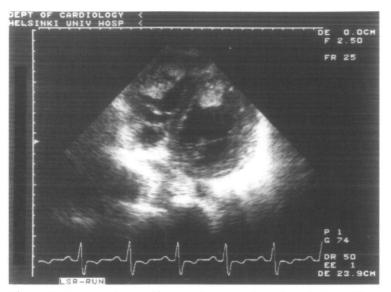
Echocardiographic two-chamber view of patient 4 with a biventricular intracavity thrombosis. Both right and left ventricles are enlarged and left ventricular walls are thickened.
